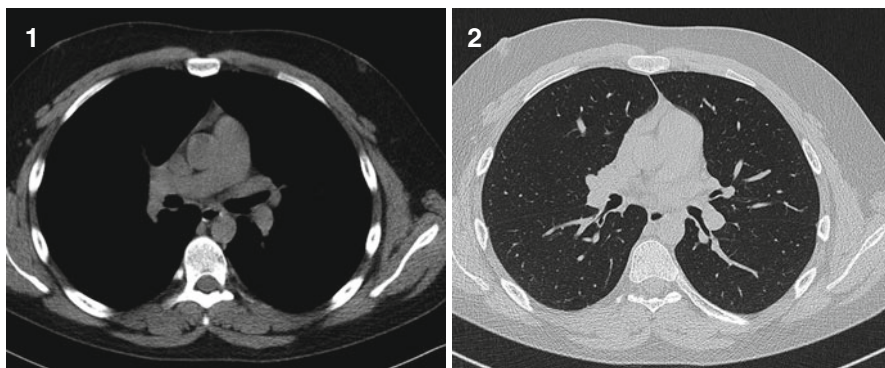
(1, 2) CT. Breast carcinoma
